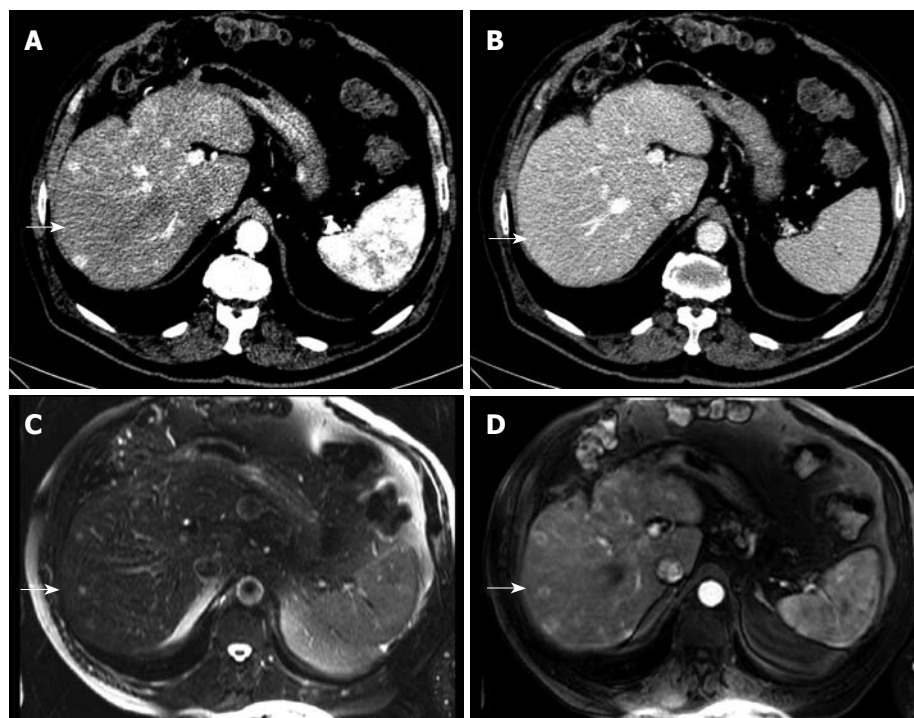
71-year-old man with biopsy-proven hepatocellular carcinoma (HCC). Detection of an additional tumor nodule by magnetic resonance imaging (MRI), size 12 mm (size category ≤ 15 mm). Multi-detector computed tomography (MDCT) demonstrates two hypervascularized tumor nodules in the contrast-enhanced arterial phase (A, arrow) but not in the portal venous phase (B, arrow). MRI arterial phase depicts one more tumor nodule (arrows) in the T2w (C) and the T1w contrast-enhanced early arterial phase (D).
